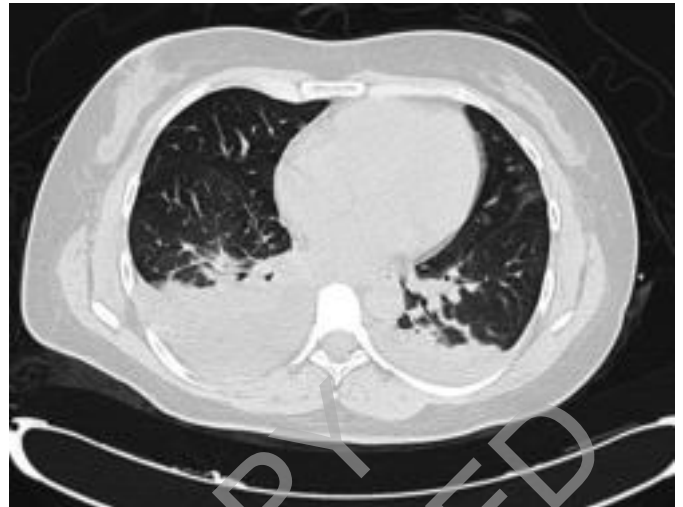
CT scan (two days after trauma) showing bilateral pulmonary contusion and right pleural effusion.
